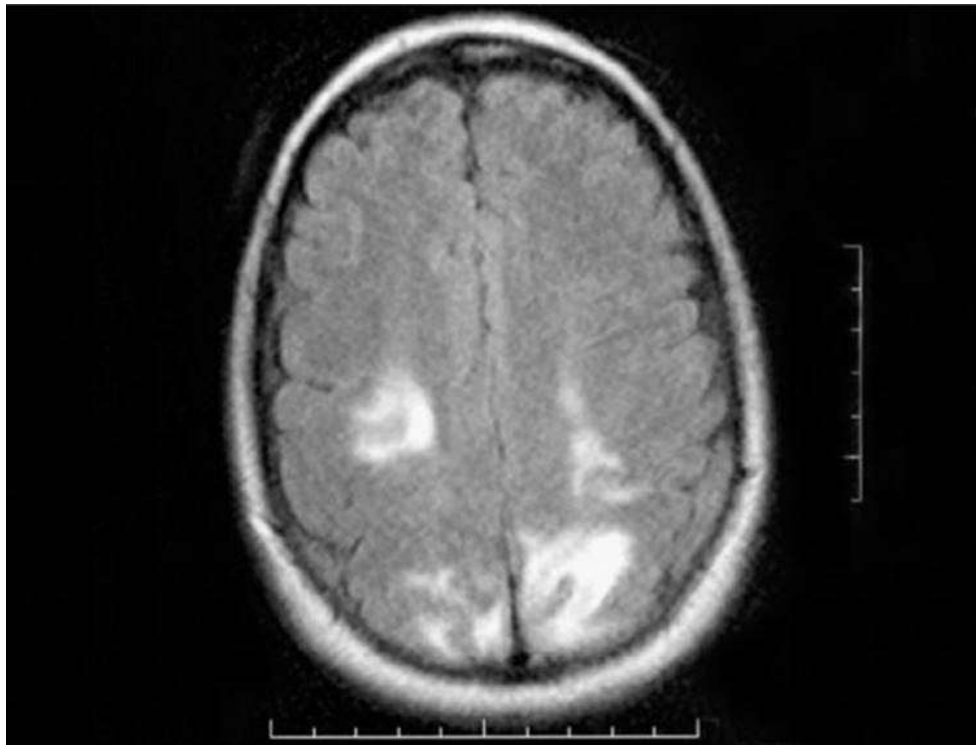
Cranial magnetic resonance imaging in a nullipara with eclampsia. Multilobe T2-FLAIR high-signal lesions are apparent. FLAIR = fluid-attenuated inversion recovery.
